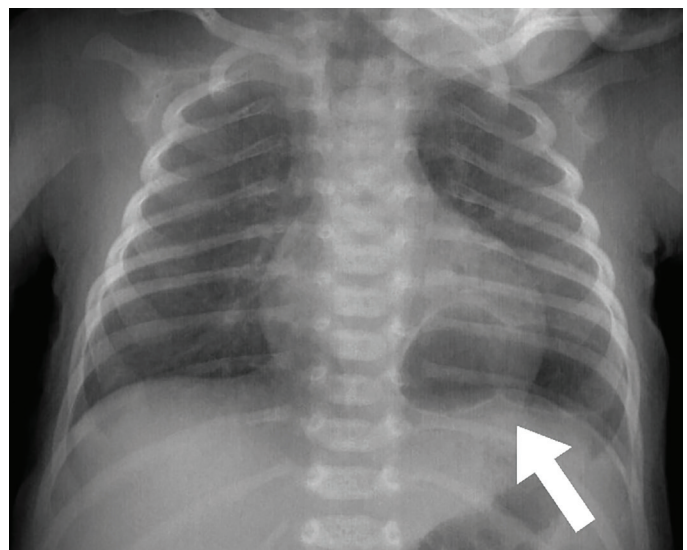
Chest X-ray shows suspicious lesion (there is a multiloculated cystic lesion which was thought to be recurrent diaphragmatic hernia) in the left lower zone
